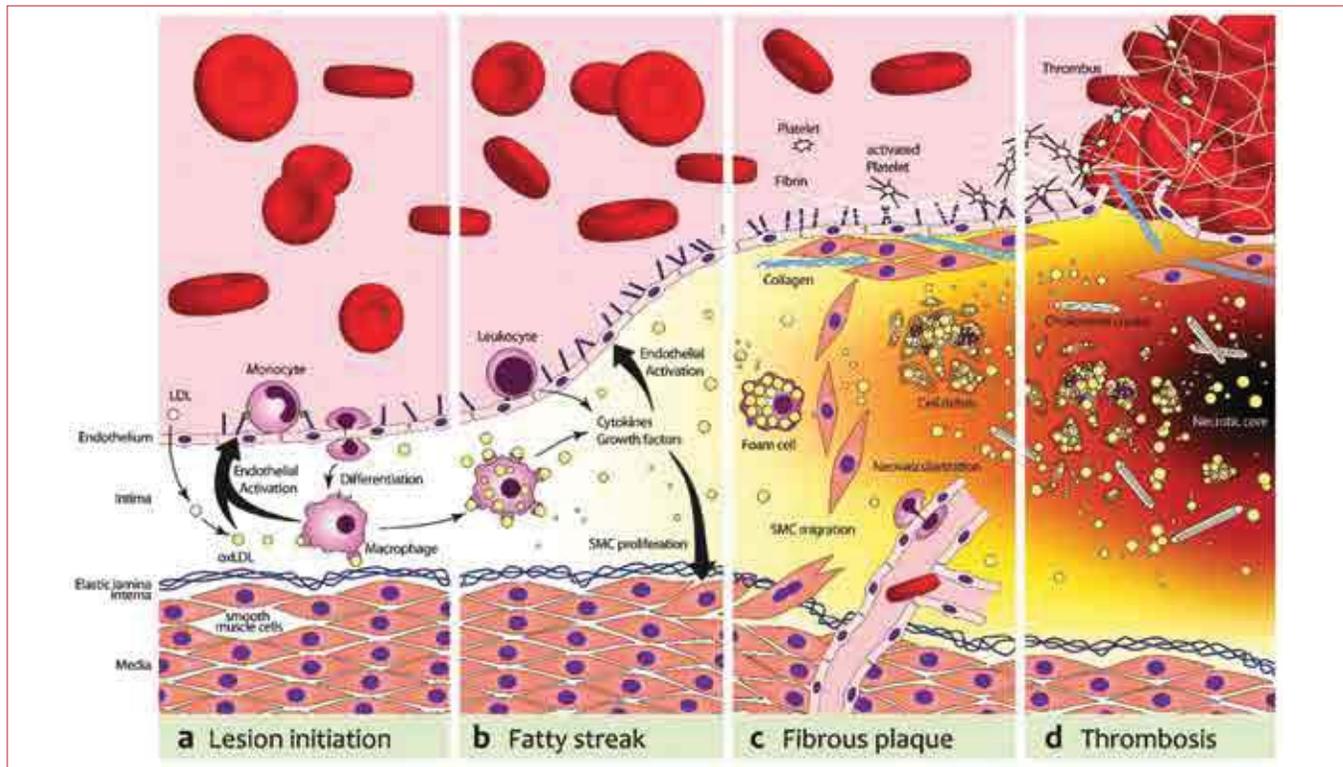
Pathogenesis of Atherosclerotic Event. (a) In the first stage, injury signals and/or low density lipoprotein (LDL) particle that deposit in the endothelium and undergo oxidative modification, resulting in oxidized LDL (oxLDL) initiate the event. These signals stimulate endothelial cells to express adhesion molecules (e.g., vascular cell adhesion molecule-1 (VCAM-1), P-Selectin) and various chemokines (e.g., Monocyte Chemoattractant Protein-1 (MCP-1), Interleukin 8 (IL-8)). This leads to a recruitment of monocytes, which transigrate into the intima and differentiate to pro-atherogenic macrophages; (b) Macrophages harvest residual oxLDL via their scavenger receptors and add to the endothelial activation and, subsequently, leukocyte recruitment with the secretion of Tumor Necrosis Factor α (TNF- α) and IL-6; (c) The increasing plaque volume promotes neovascularization. Proliferating smooth muscle cells (SMCs) stabilize the nascent fibrous plaque. With deposition of fibrin and activated platelets on the dysfunctional endothelium that expresses tissue factor (TF) and von Willebrand factor (vWF), a pro-thrombotic milieu is formed; (d) Foam cells can undergo apoptosis and release cell-debris and lipids, which will result in the formation of a necrotic core. In addition, matrix metalloproteases secreted from foam cells can destabilize the plaque. This can lead to plaque rupture, in which case extracellular matrix molecules (e.g., collagens, elastin, TF, vWF) catalyze thrombotic events. From Steini DC, Kaufmann BA. Ultrasound imaging for risk assessment in atherosclerosis. *Int J Mol Sci.* 2015 Apr 29;16(5):9749-69.
